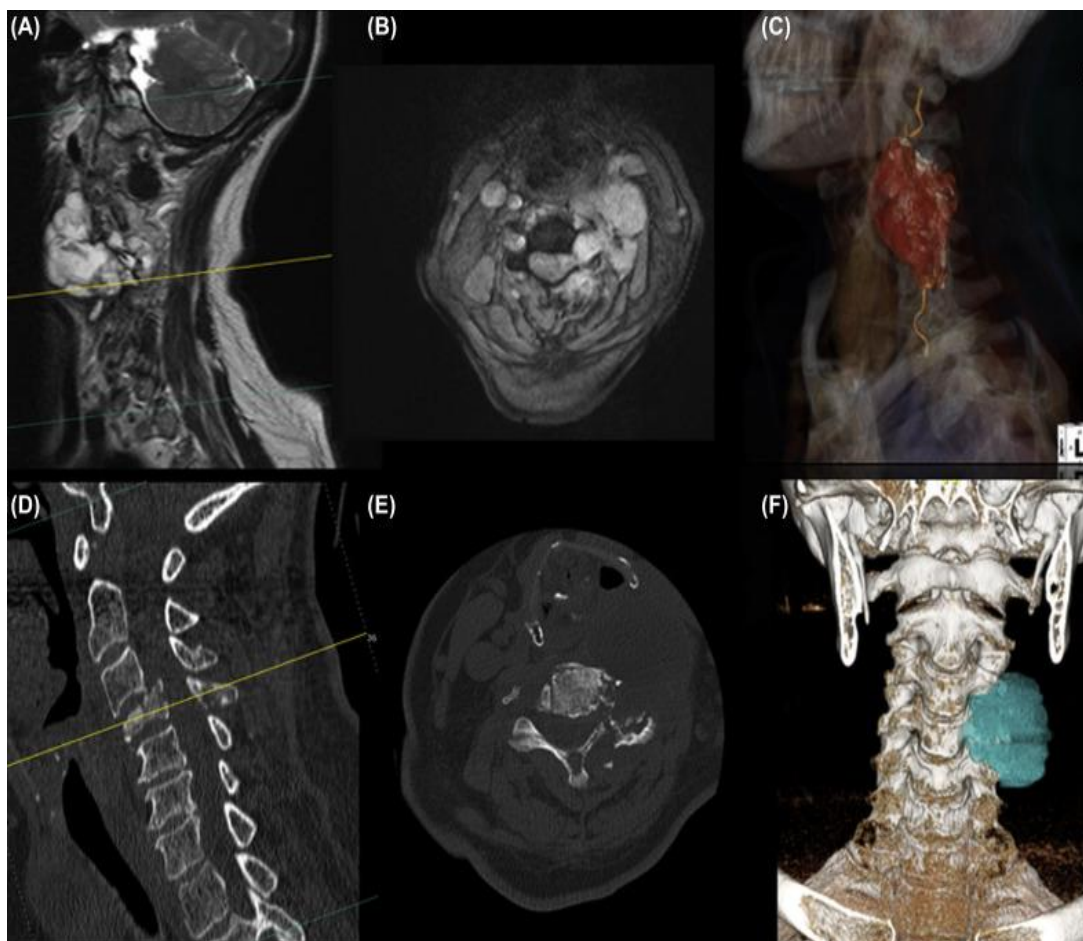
Sagittal (A) and axial (B) magnetic resonance imaging of the cervical spine (T2 sequence) demonstrating a chondrosarcoma involving the C3, C4, and C5 vertebral bodies. The tumor extends anterolaterally encompassing the left vertebral artery [C – computed tomography (CT)–angio reconstruction] as well as infiltrating the left C3, C4, and C5 nerve roots. Sagittal (D), axial (E), and three-dimensional reconstruction (F) of CT scan of the cervical spine in the same patient demonstrating a pathological compression fracture of the C4 vertebral body with destruction of the left side facets, pedicle, and lamina by tumoral infiltration.
